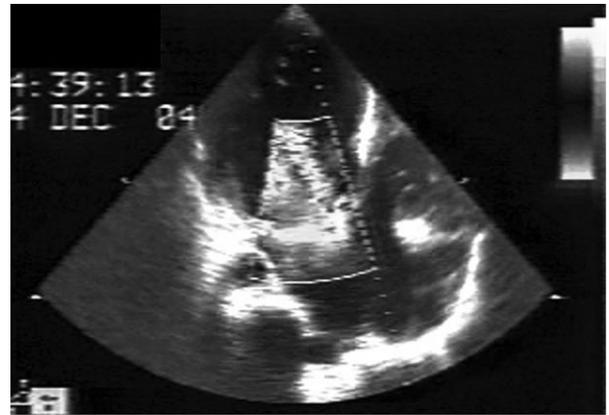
Apical five chamber view showing the regurgitant aortic jet.
